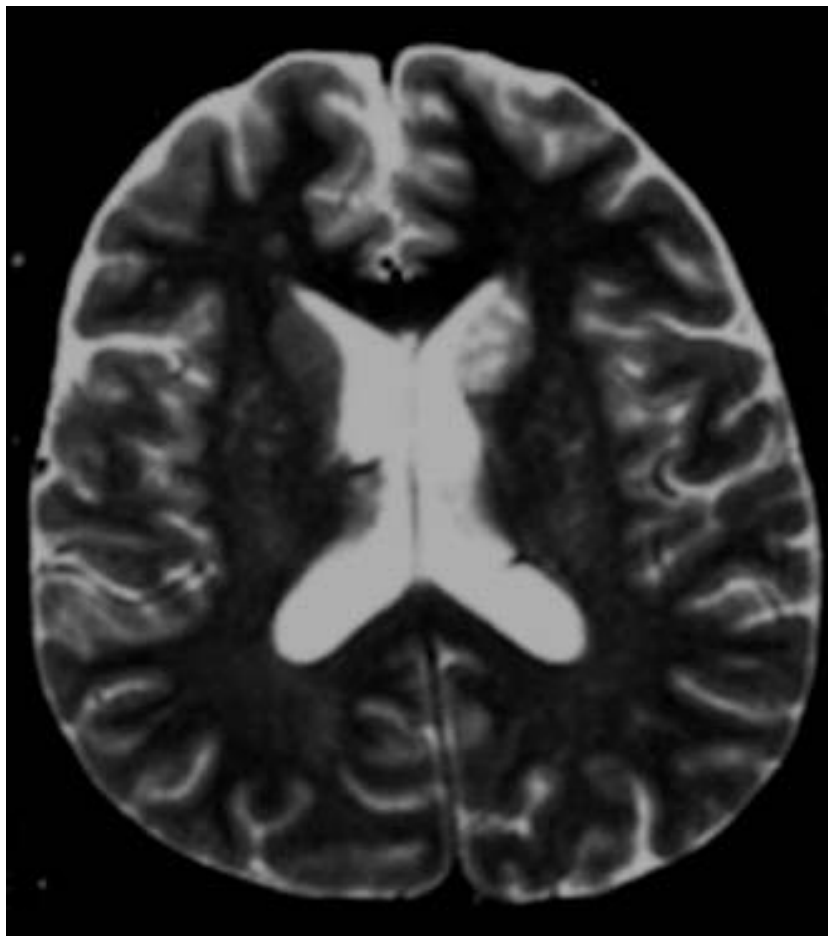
CT brain of HIV dementia-dilated ventricles, cerebral atrophy
